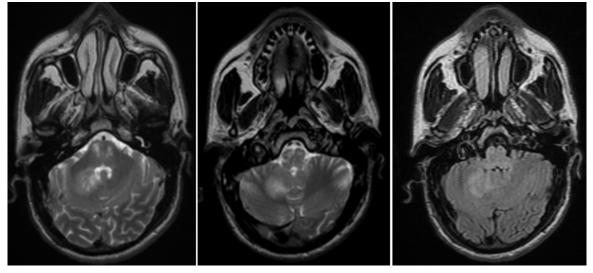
Abnormal Tumor-Like T2WI/FLAIR Hyperintense Signals Seen in the Right Cerebellum.
